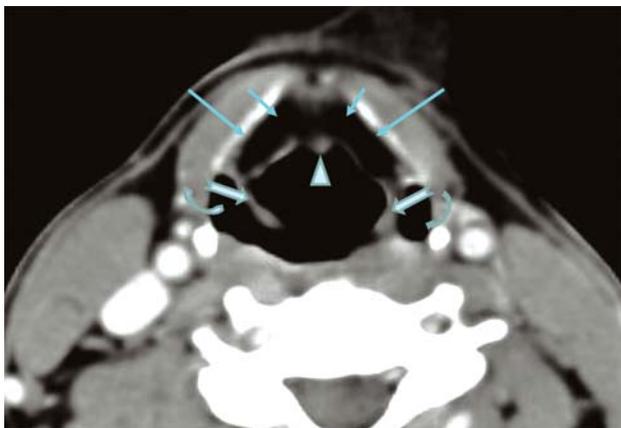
Axial CT scan through the supraglottis showing the epiglottis (arrowhead), aryepiglottic folds (notched arrows), thyroid lamina (lines) and pyriform sinuses (curved arrows). The pre-epiglottic space is filled with fat (arrows)
